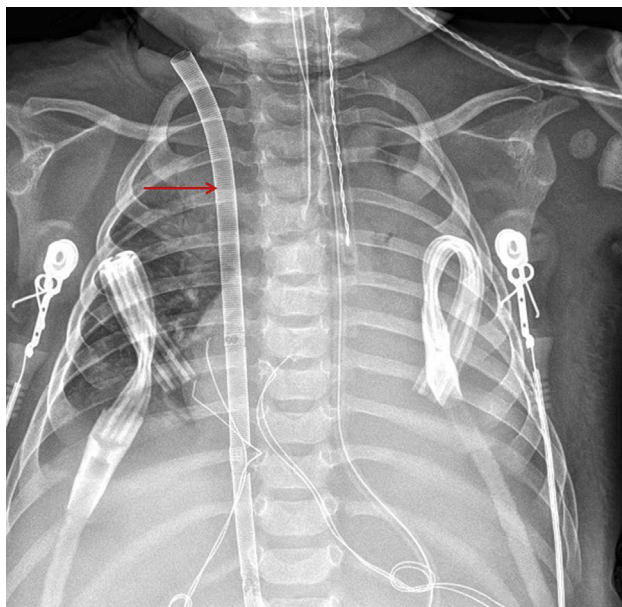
Chest radiograph on postoperative day 9. The arrow demonstrates extracorporeal membrane oxygenation cannula.
